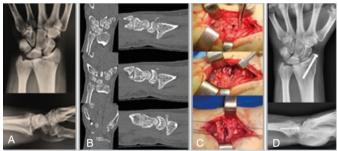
A) Dumontier's Type II, B) CT scans showing dorsal dislocations, C) Severe lesion of volar extrinsic ligaments and it's repair, D) Final radiographs.
